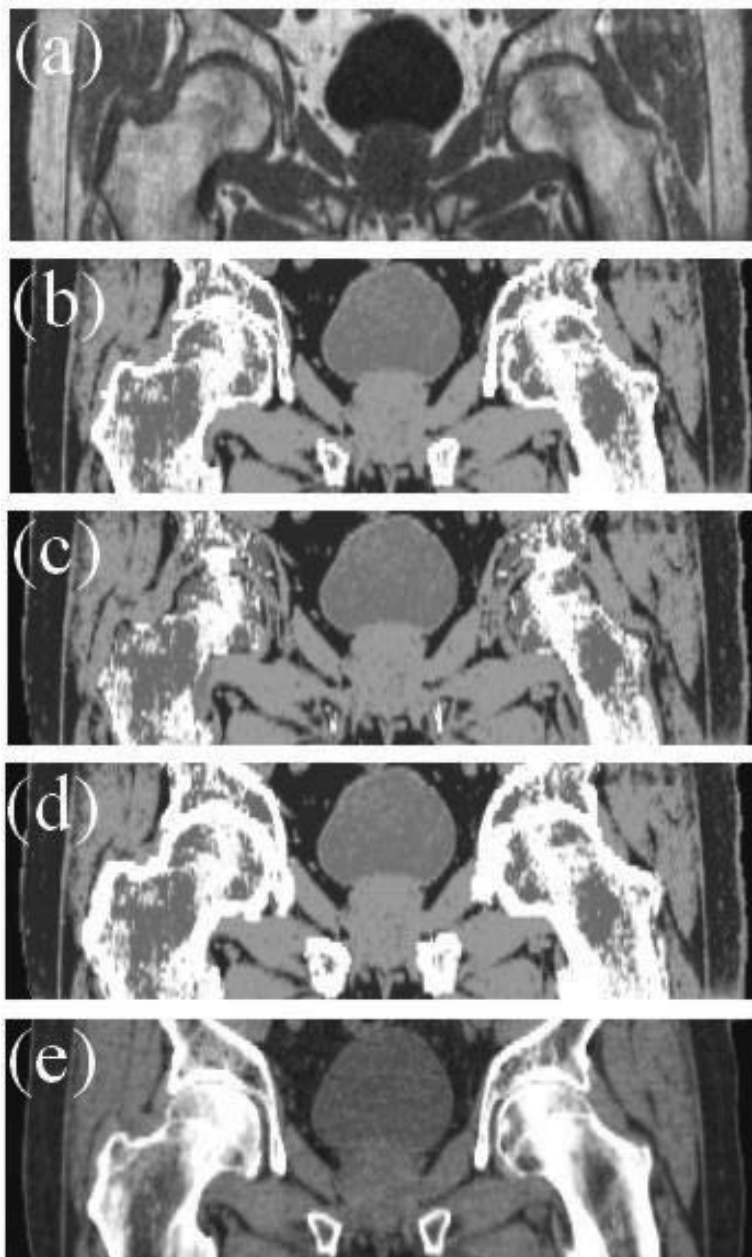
Example coronal views of the heterogeneous pseudo-CTs obtained by the dual model pseudo-HU conversion technique with precise (b), 3 mm too narrow (c), and 3 mm too wide (d) bone segments demonstrating the influence of segmentation errors to the generated pseudo-CT image. The original MR image and the corresponding CT image are shown in (a) and (e), respectively. Contrast in the images is not perfectly comparable (different windowing properties and scaling).
